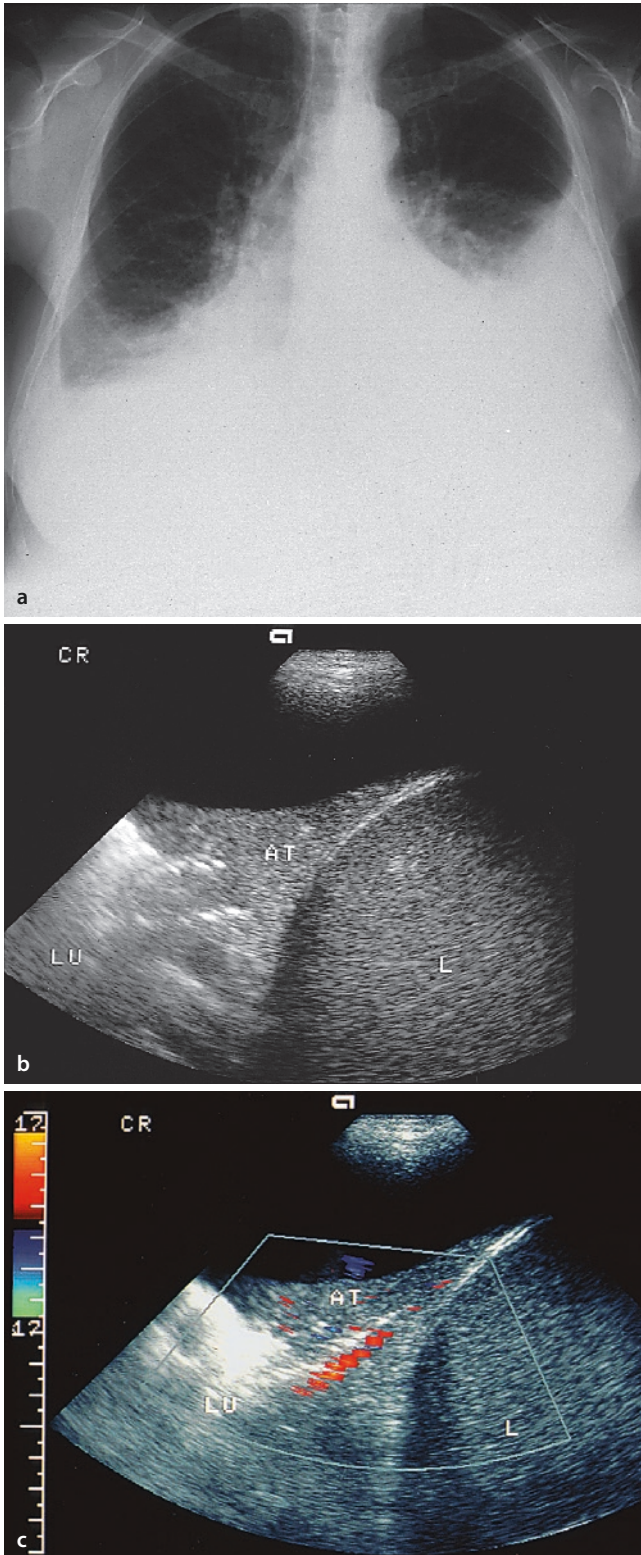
a Chest X-ray: a 60-year-old man with global decompensated heart failure and bilateral pleural effusions. b Sonography: In right-lateral intercostal echo transmission one sees a pleural effusion with a wedge-shaped hypoechoic transformation of parts of the lower lobe of the lung as in the presence of atelectasis (AT). The demarcation to the ventilated lung (LU) is blurred. An extensive “air bronchogram” is seen. L liver. c Color-Doppler sonography reveals a flow signal along the bronchial branch filled with air
